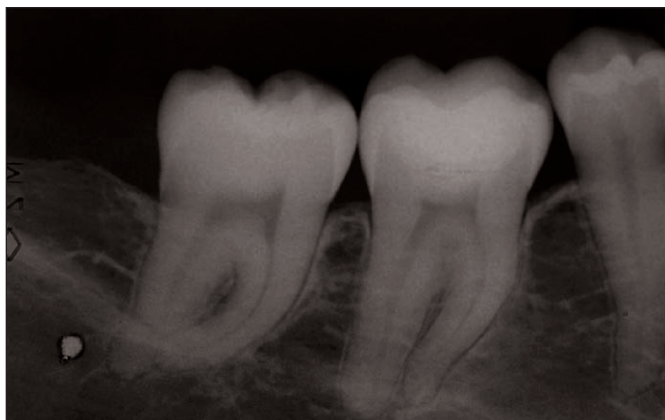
Normality of the periapical radiograph at the 17-year control.
